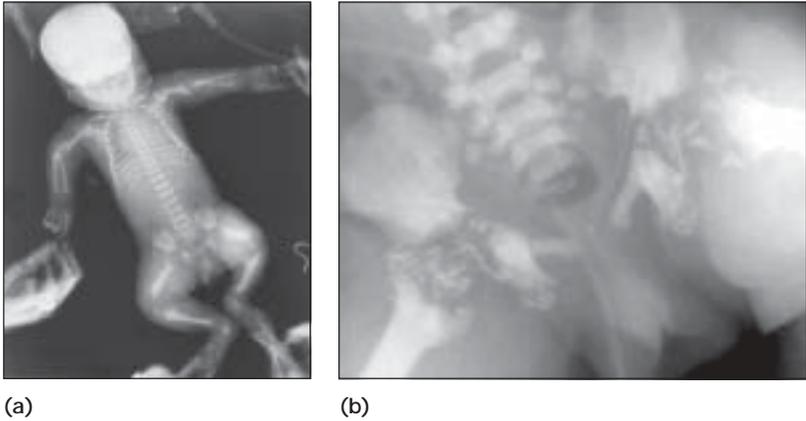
A radiograph of a neonate with the peroxisomal disorder- rhizomelic chondrodysplasia punctata. a Whole baby b Pelvis and hips
